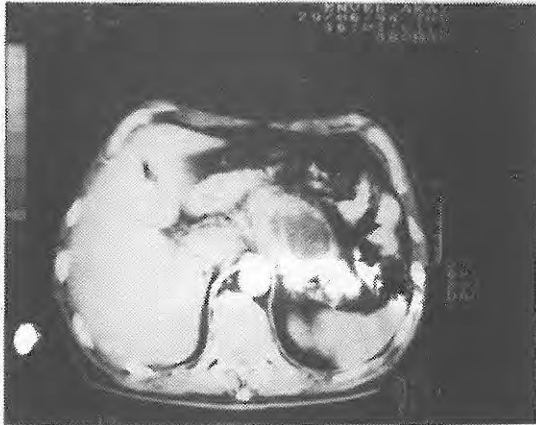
B. CT shows pseudocyst formation in the pancreatic corpus-tail region
